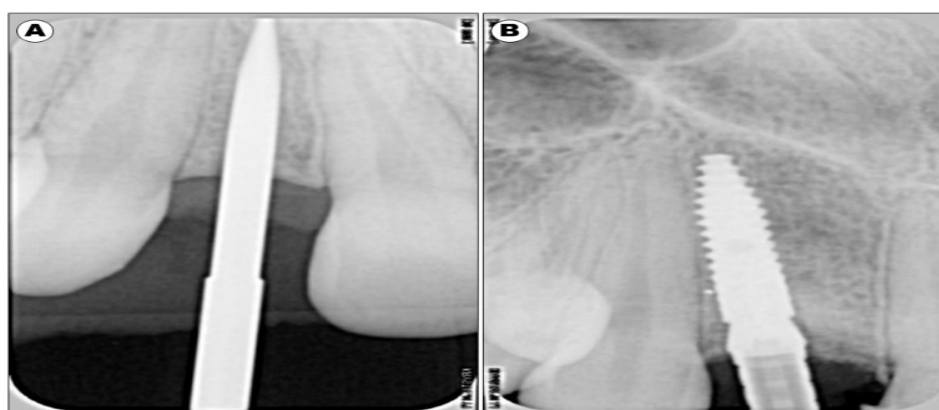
Trans- and postoperative periapical radiographs of region 12 A: Parallelometer in position for drilling check B: Immediate postoperative period after implant placement with oval temporary abutment for crown
